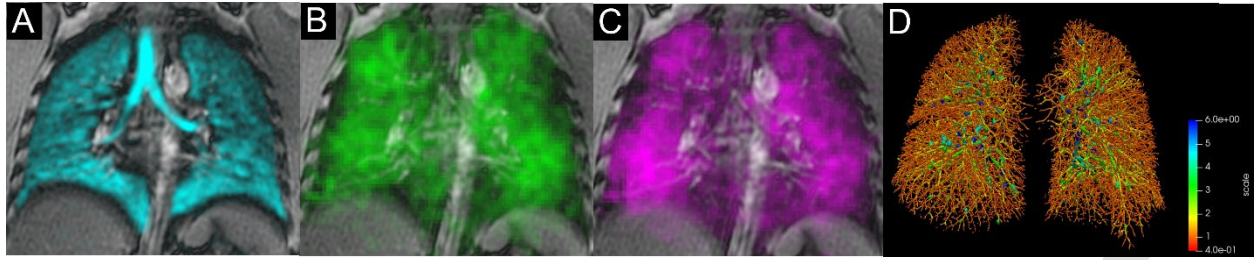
$^{129}\text{Xe}$  gas-transfer MRI in a 30-year-old male control participant with RBC:barrier ratio=0.52. A)  $^{129}\text{Xe}$  ventilation MRI B)  $^{129}\text{Xe}$  barrier MRI C)  $^{129}\text{Xe}$  red-blood-cell (RBC) MRI.
